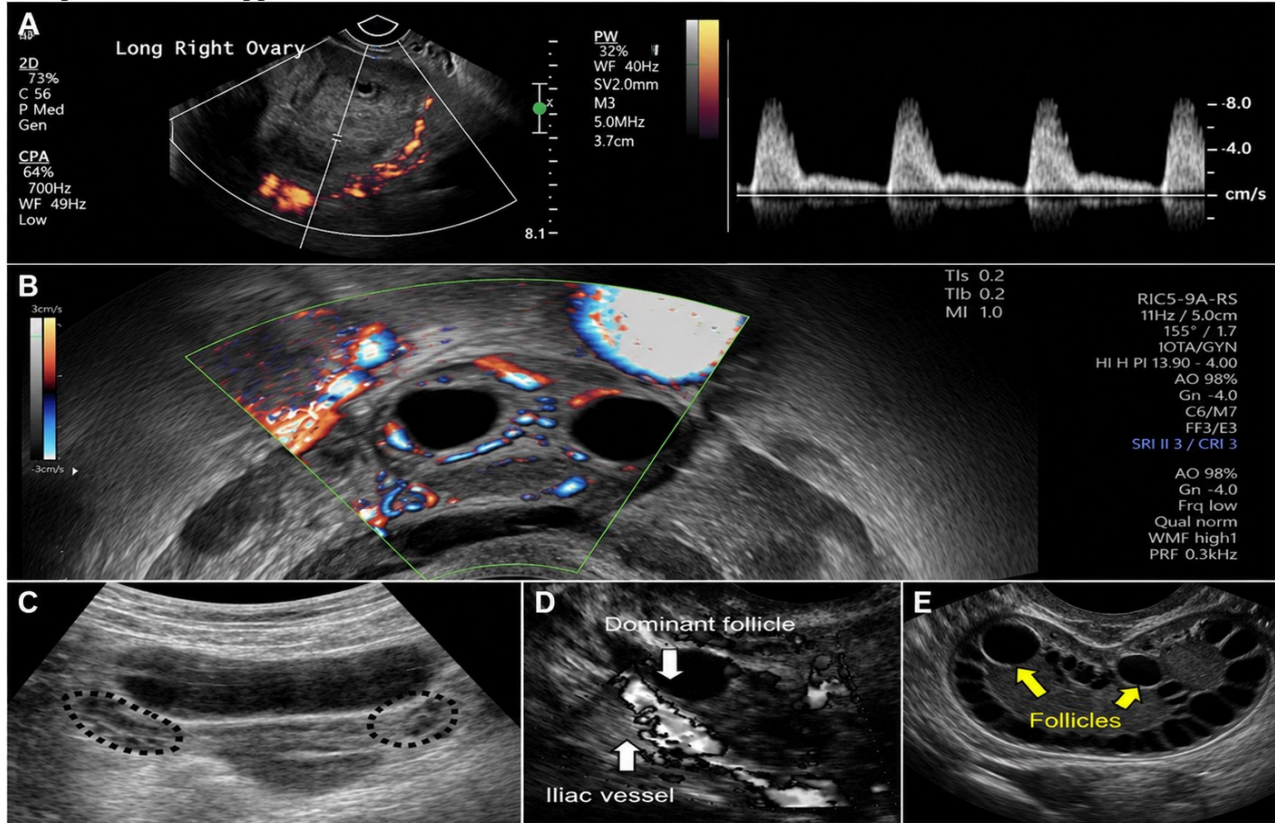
Ultrasound evaluation of polycystic ovary morphology (PCOM) and stromal vascularity. (A) Transvaginal color Doppler with spectral waveform showing increased stromal blood flow and low-resistance pattern. (B) Color Doppler demonstrating perfollicular and stromal vascularity. (C) Multiple peripheral follicles peripherally (dotted circles). (D) Dominant follicle with adjacent iliac vessel on color Doppler. (E) Multiple peripheral follicles (arrows) producing a “string of pearls” appearance, characteristic of PCOM.
